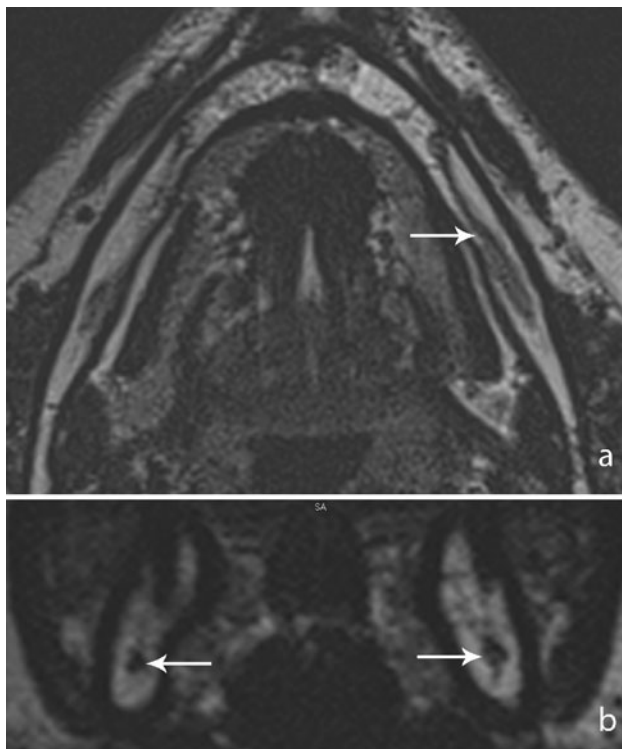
Axial (a) and coronal (b) T2-weighted image of the mandible. Arrows clearly demarcated mandibular canal
